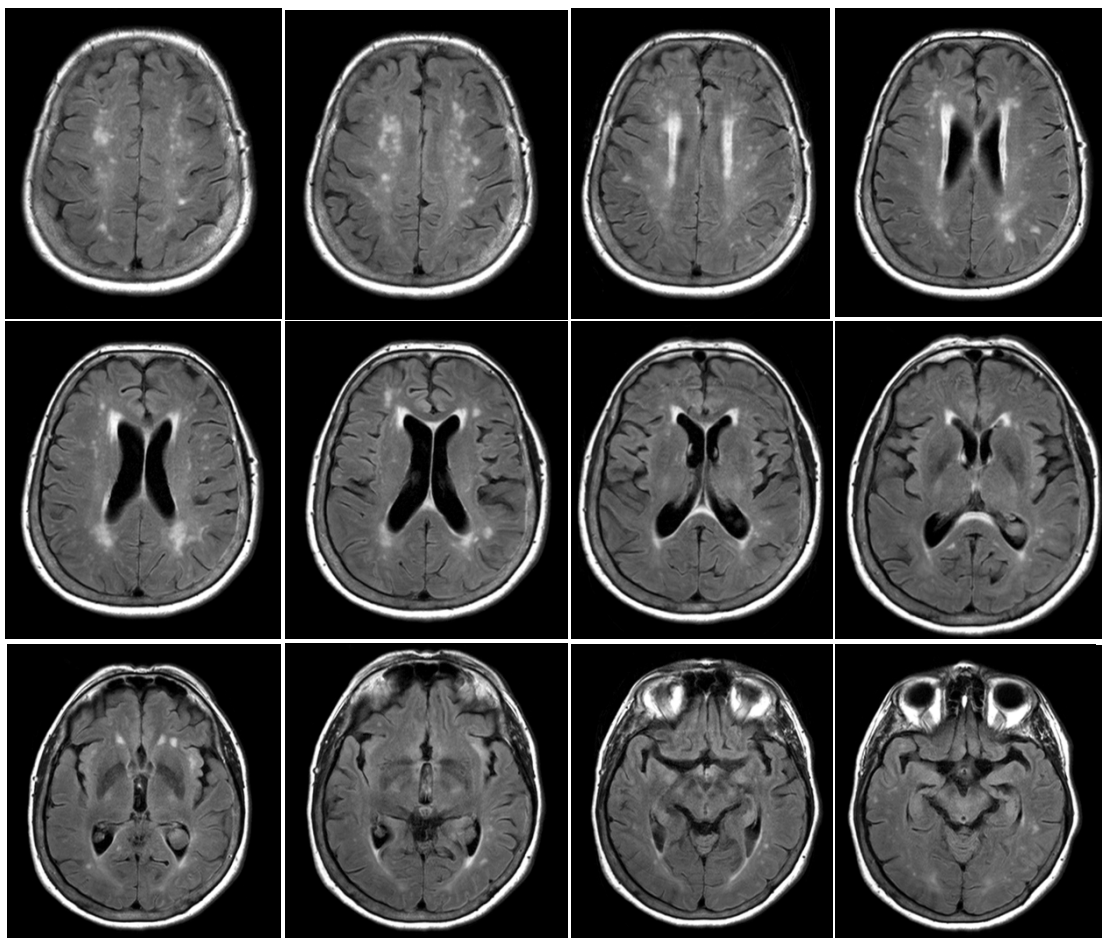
Migraines. Female, 71yo, right-handed, presenting with sensory symptoms. MoCA score of 29. Strong presence of WMH with a Scheltens score of 55, and a history of migraines. Initial and final diagnose of migraine. FLAIR image.
